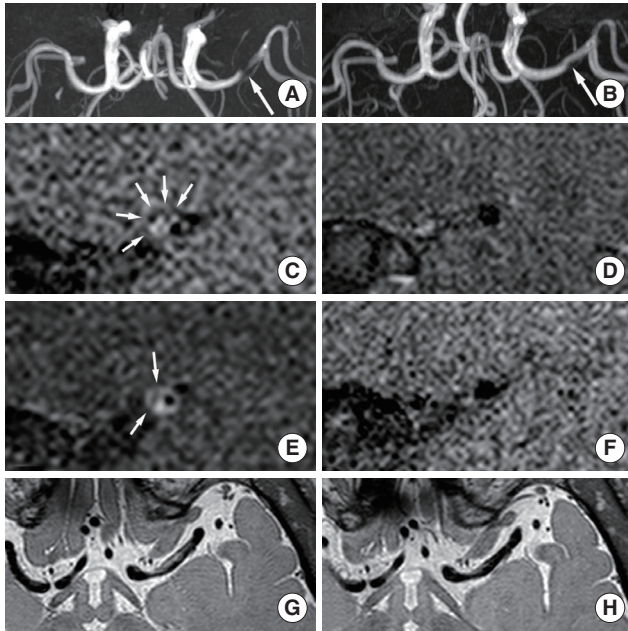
Intracranial artery dissection. A 50-year-old male patient with one atherosclerotic risk factor (smoking) presented with right-side weakness. (A) Time-of-flight magnetic resonance angiograph showing severe stenosis in the left middle cerebral artery (arrow). (C) Intramural hematoma showing hyperintensity on T1-weighted imaging (small arrows), and (E) the intimal flap seen on contrast-enhanced T1-weighted imaging (small arrows). (G) Segmental aneurysmal dilatation seen on proton-density imaging. (B) One year later, the dissecting lumen improved (arrow), and (D, F, H) the aforementioned findings disappeared. The patient was considered to have had a middle cerebral artery dissection; however, intraplaque hemorrhage underlying atherosclerosis could not be excluded completely.
